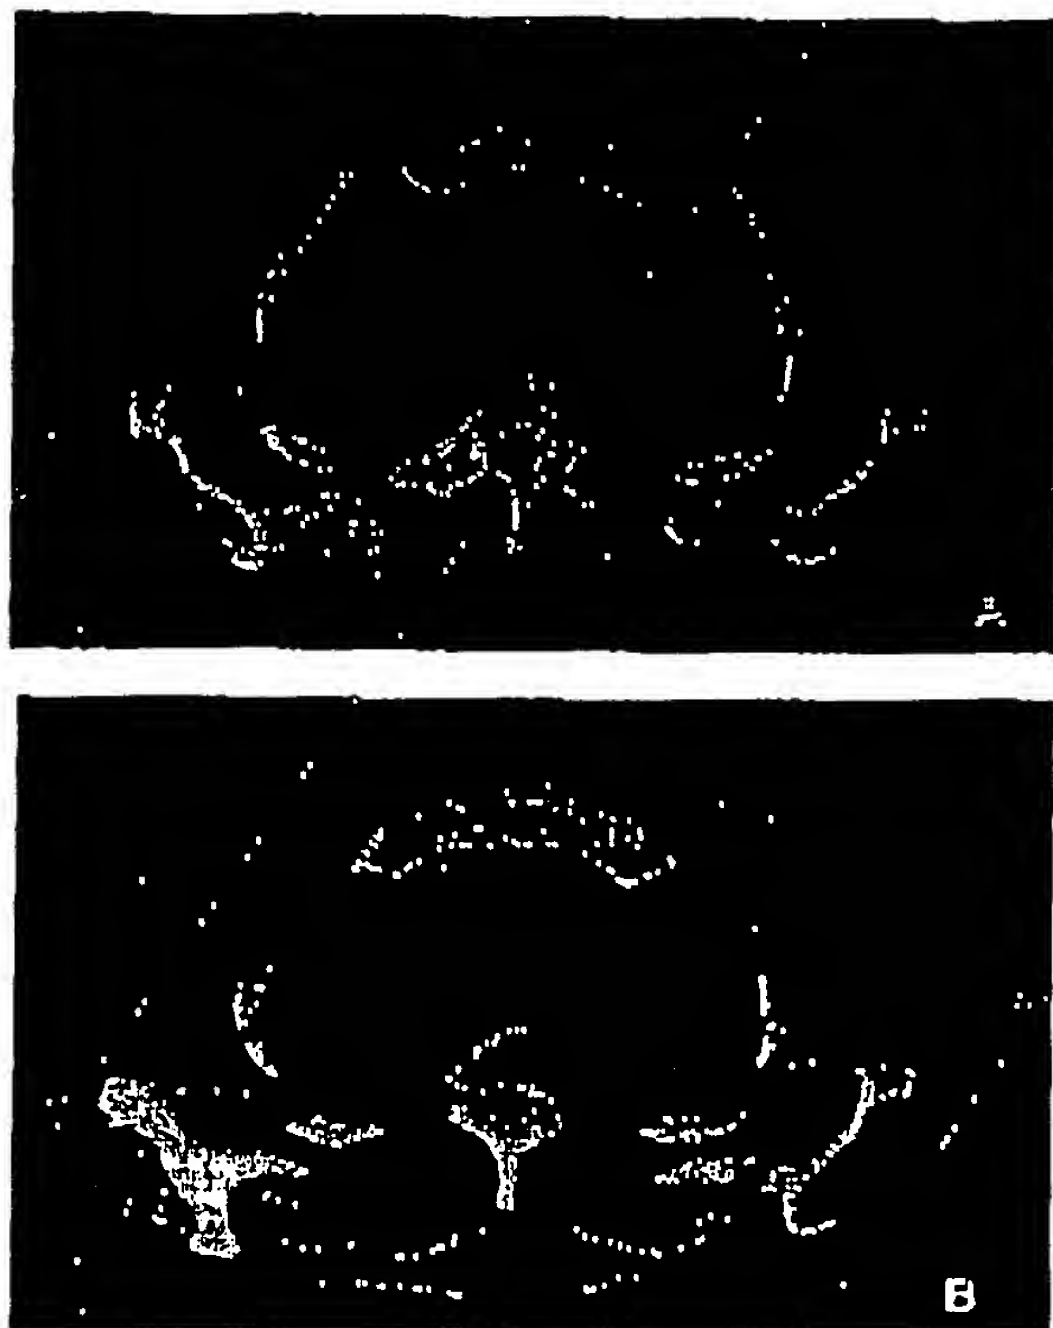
Computed tomography scan for patient 8
